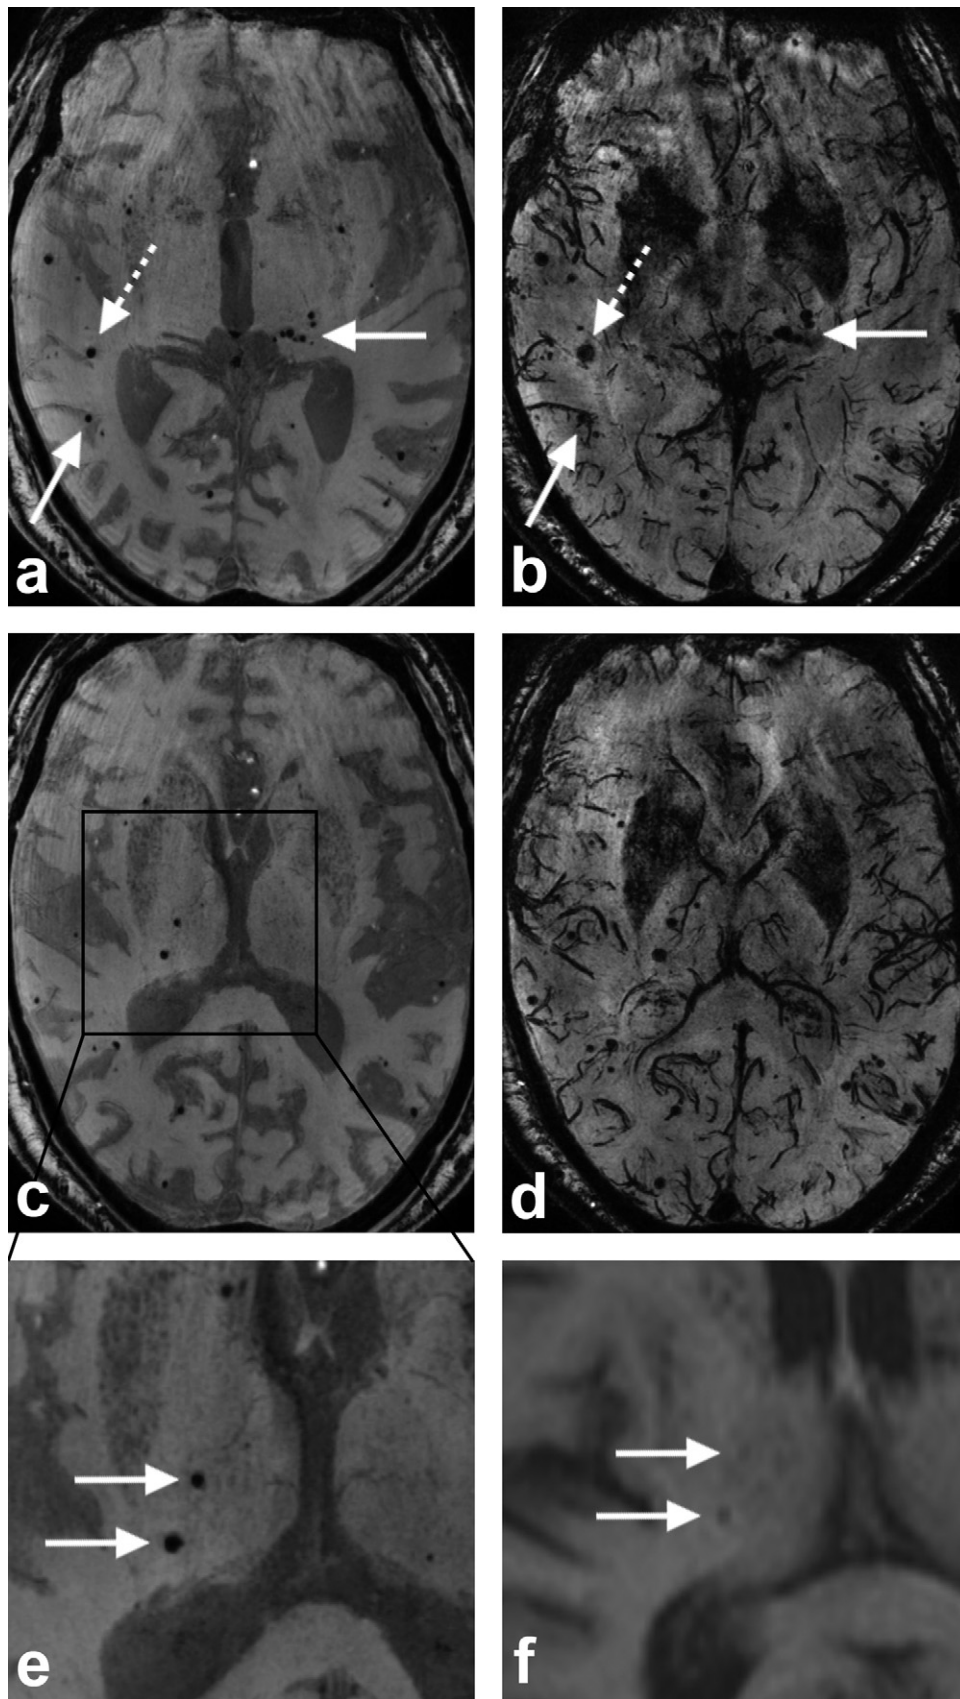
77-year-old man with a history of hypertension presented with transient dysphasia based on a transient ischemic attack (TIA) of the left hemisphere. a, c, Axial minimal intensity projections (minMIPs) over 10 mm thick volumes of the 1st and b, d, minMIPs of the 2nd echo of 7 T T_2^* -weighted images, where multiple microbleeds can be found throughout the brain (arrows). Some are less easily distinguished on the 2nd echo minMIPs due to overlapping venous structures (striped arrows) and artefacts close to the nasal cavity. e, Zoomed-in image of 7 T and f, of standard clinical 1.5 T 1st echo minMIPs, showing better visualization of the microbleeds due to the increased susceptibility effects at 7 T compared to 1.5 T MRI. Imaging parameters as previously published [33].
